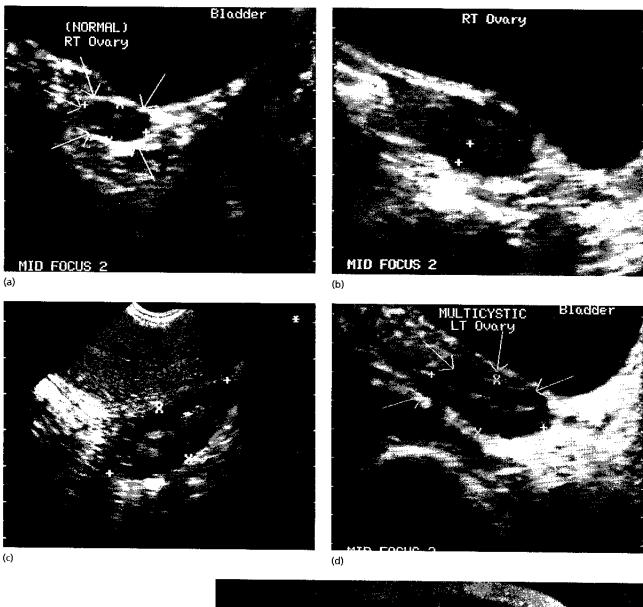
(a) Transabdominal ultrasound scan of a normal ovary.
